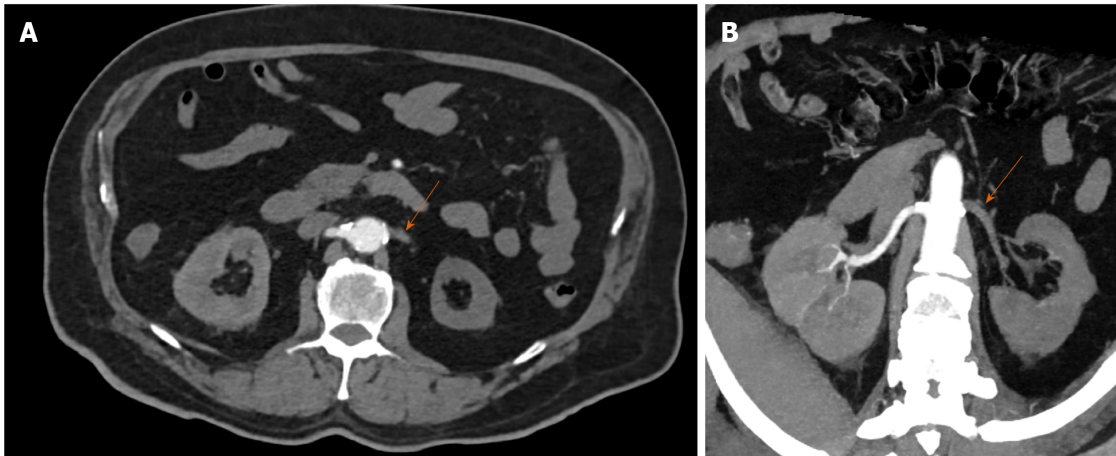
A 74-year-old male with renal artery thrombosis. A and B: Axial baseline and oblique coronal reformatted maximum intensity projection images of arterial phase contrast-enhanced computed tomography images showing hypodense filling defect involving left renal artery from ostium to hilum and its segmental branches with non-enhancement of left kidney suggestive of left renal artery thrombosis with infarct.
